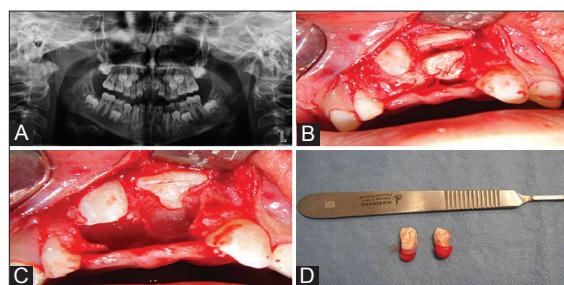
A: Impacted tuberculate type supernumerary teeth are observed on the panoramic radiograph on maxillary anterior region B: Supernumerary teeth are palatally located. C: Intraoperative appearance after removal of supernumerary teeth. D: Appearance of supernumerary teeth after removal
